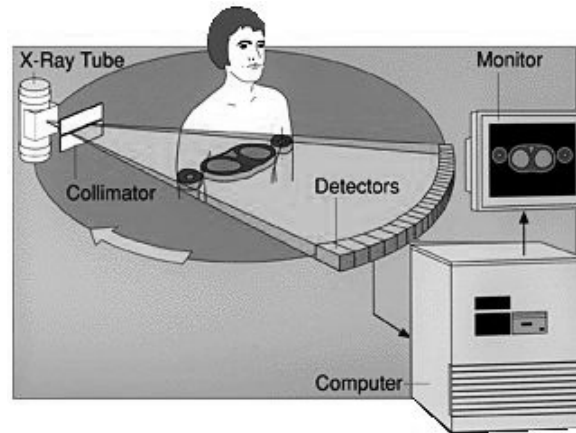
Computed Tomography: scheme. Projection data obtained from the attenuation of X-rays radiations is converted in density (Hounsfield Units) images from proper algorithms.
